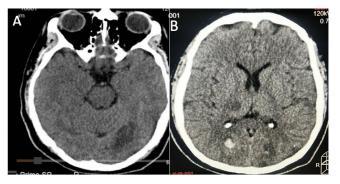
A) Simple head CT scan with ischemic lesion in left occipital lobe. B) Simple head CT scan with multiple hemorrhagic and ischemic lesions in both occipital lobes.
